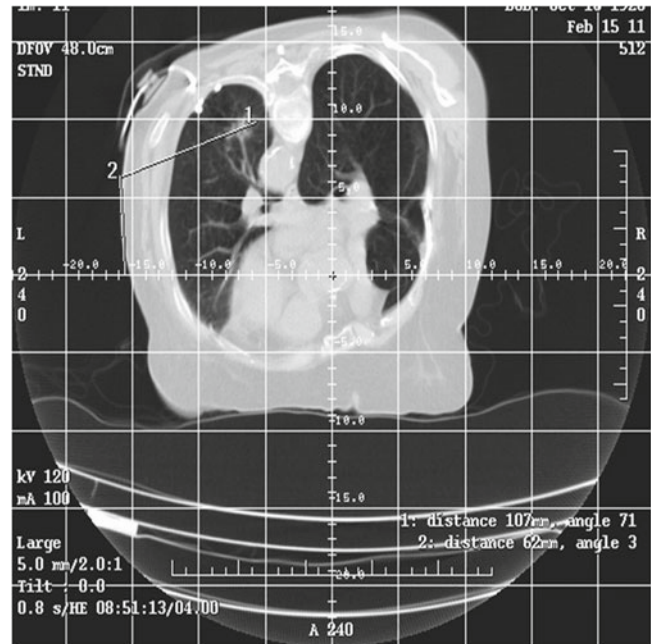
An 84-year-old woman with left lower lobe adenocarcinoma was referred for microwave ablation. (a). Axial CT image with the patient prone shows the computerized grid that is used to select the safest skin entry site, trajectory, and distance to the tumor. On the lower right of the image, the distance in mm (line 2) from the lateral laser light indicates the skin entry site for that particular CT slice (e.g., table position), and line 1 indicates the distance in mm and trajectory angle perpendicular to the tumor
